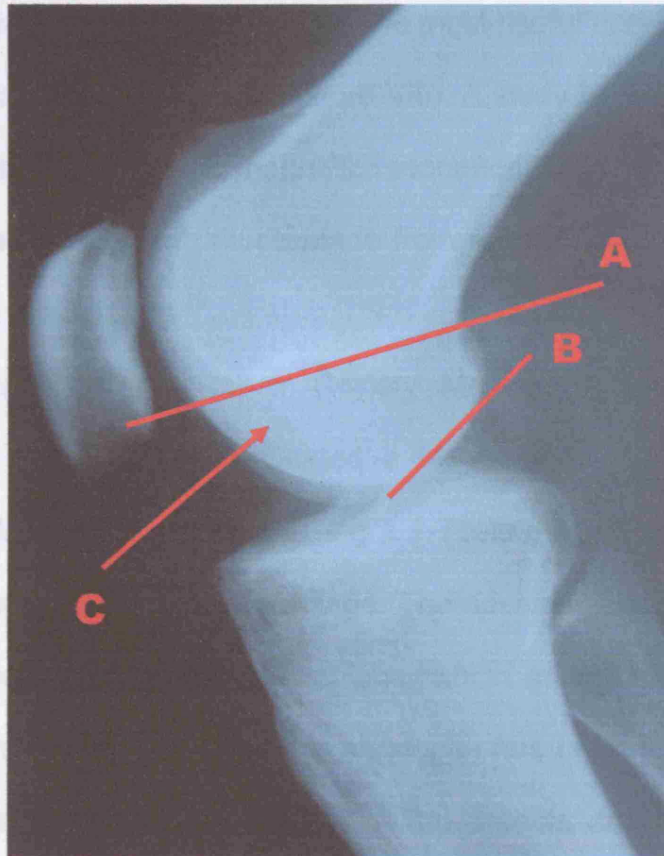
Lateral radiograph of the knee demonstrating the Blumensaat line (A), and a line drawn along the posterior femoral cortex (B). Between these 2 lines Harding found a high incidence of osteochondritis dissecans (C).
